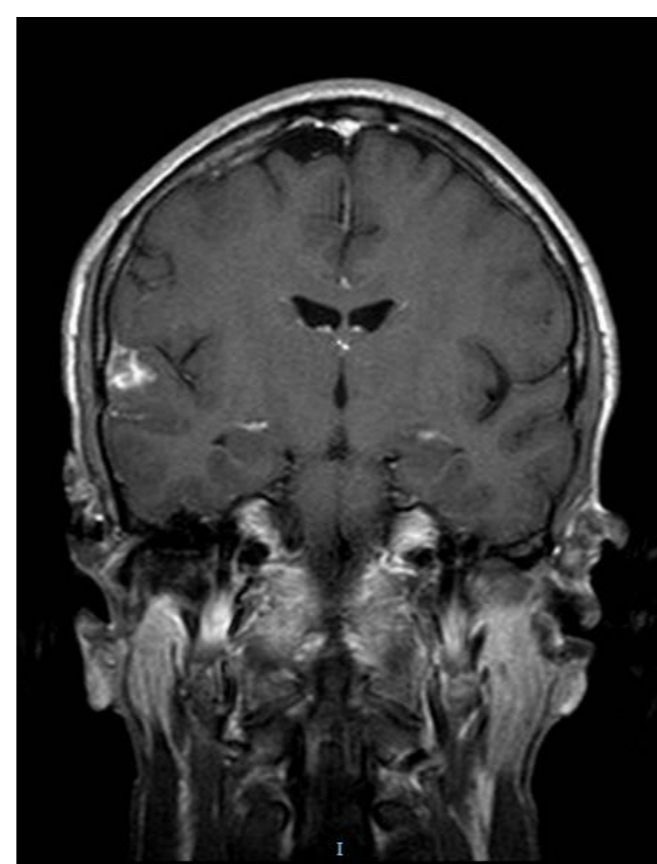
MRI T1 GD, coronal scan
